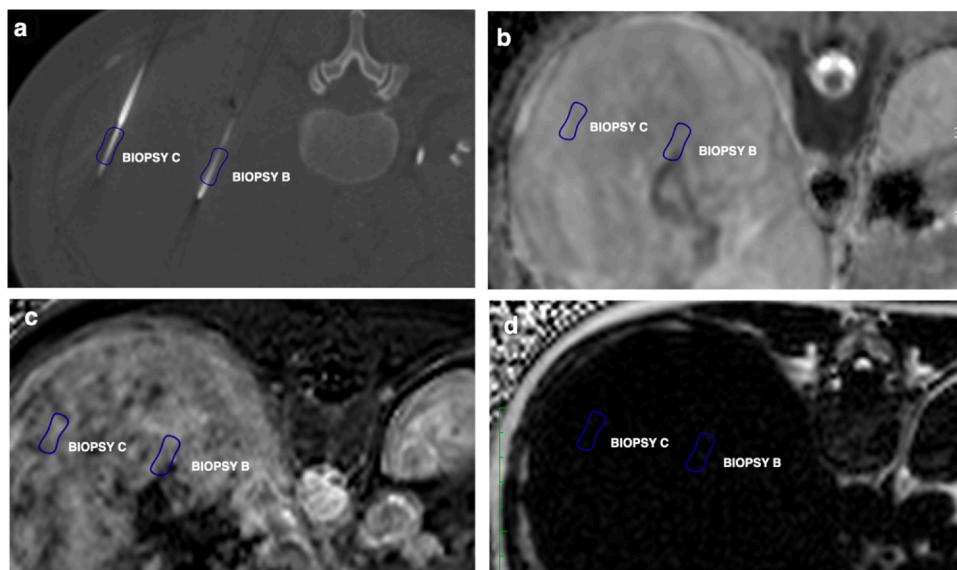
Extraction of quantitative imaging metrics from precise biopsy sites in a 57-year-old woman with dedifferentiated liposarcoma. (a) Unenhanced axial plane CT image previously registered with the MRI using point-based registration. Two regions of interest are contoured to overlie biopsy needle side notches (for target regions b and c). (b) Extraction of apparent diffusion coefficient (ADC) values at biopsy sites (mean ADC value $1568 \times 10^{-6} \text{ mm}^2/\text{s}$ in region b and $1892 \times 10^{-6} \text{ mm}^2/\text{s}$ in region c). (c) Extraction of the enhancement fraction (EF) (42.5 in region B and 40.0 in region c). (d) Extraction of the fat fraction (FF) map (mean FF 2.1% in region b and 2.2% in region c).
